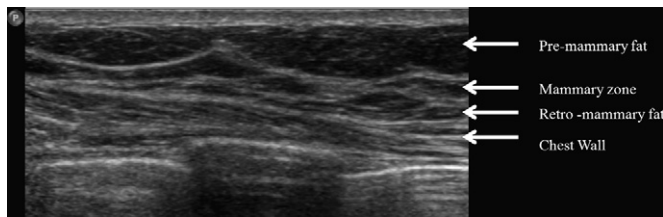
Transverse sonographic image of normal breast tissue. Pre-, intra-, and retromammary fat appears as the most hypoechoic structure.
